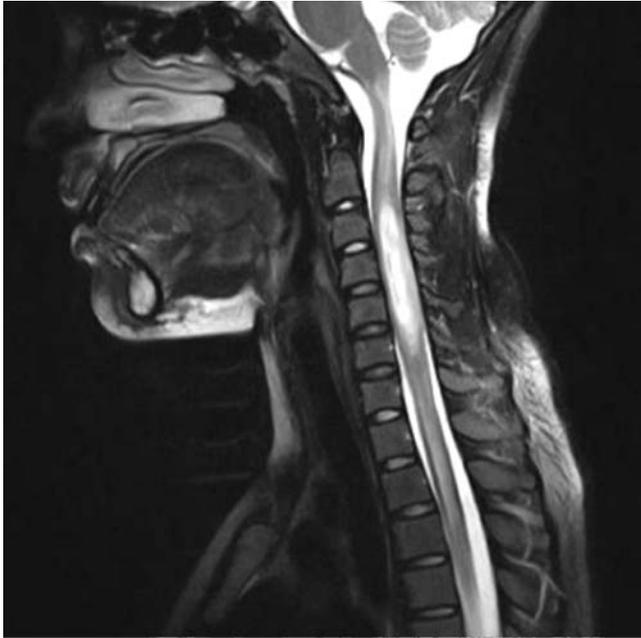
T2 weighted MR image of the same girl, showing a hyperintense, sausage shaped intramedullary lesion, extending from C3 to C6. It is causing expansion of the spinal cord, and there are hyperintense signal changes in the cord, proximal and distal to the lesion.
